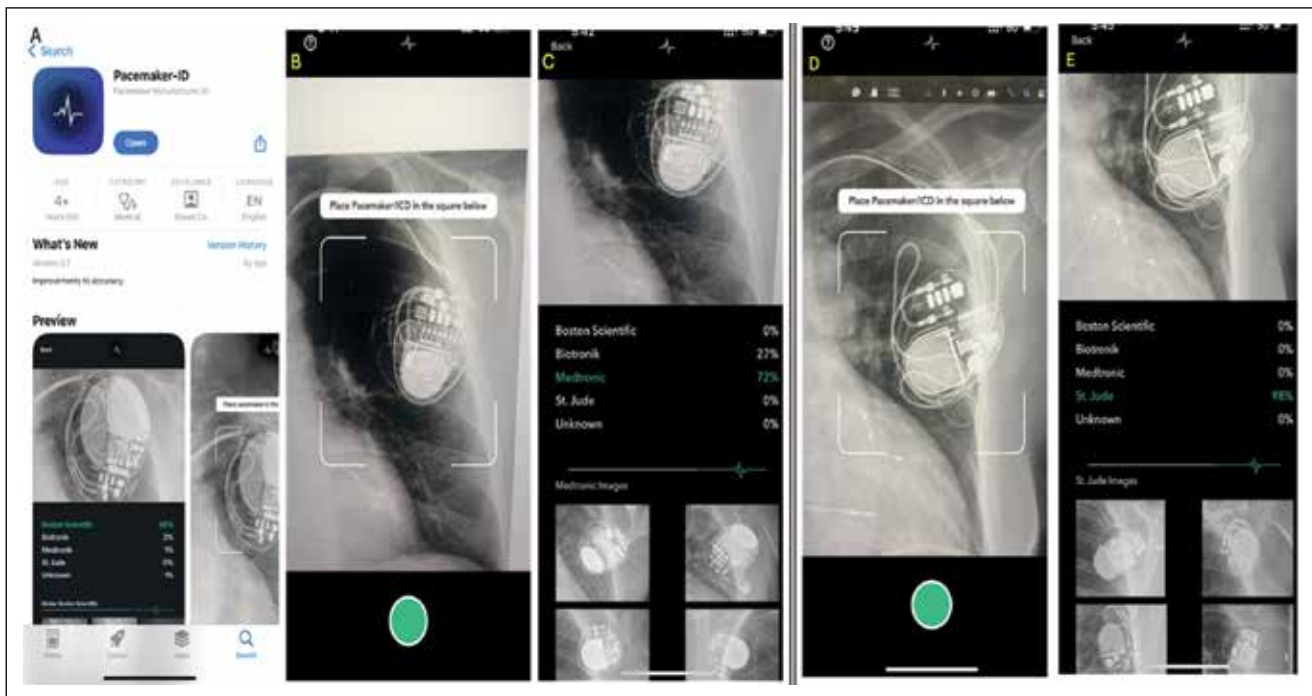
This image series demonstrates an AI-based application called pacemaker-ID (A) and its utility. Scanning the pacemaker pulse generators on a radiograph will give the likely possible manufacturer of that device in terms of percentage probability (B, C, and D, E show an example of pulse generators and their probability) and is noted to be appropriate.
